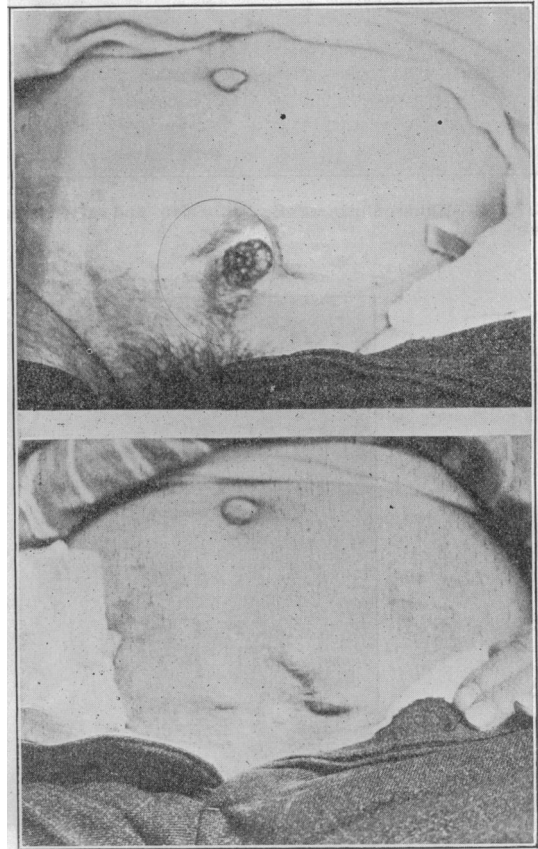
Tubercular Ulcer with Sinus leading into bladder. Closed by X-Ray applications after cauterizing had failed.
